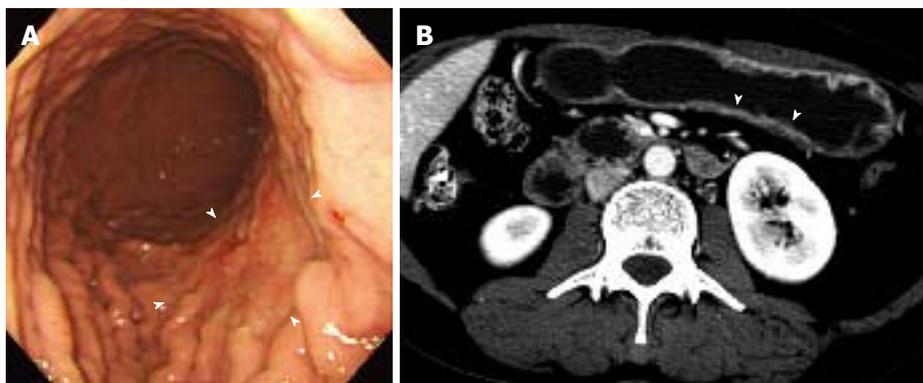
Early gastric cancer in a 45-year-old woman. The size of tumor was 9.5 cm at the longest diameter and the tumor extended to submucosal layer. A: The gastroscopy shows a large ill-defined lesion with abnormal convergence of gastric folds in posterior wall of gastric mid body (arrowheads); B: The transverse computed tomography scan shows equivocal enhancement and thickening (arrowheads) in posterior wall of gastric mid body. Although one reviewer indicated this lesion on both blinded and unblinded analysis, the other did not find this lesion even on unblinded analysis.
